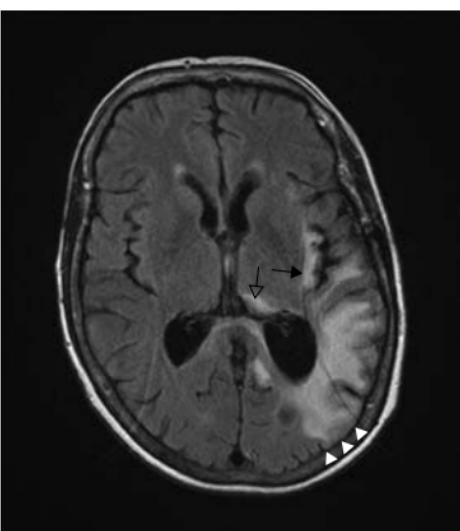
Cerebral vasculitis. (a) Axial T2-weighted and (b) axial FLAIR MRI.
